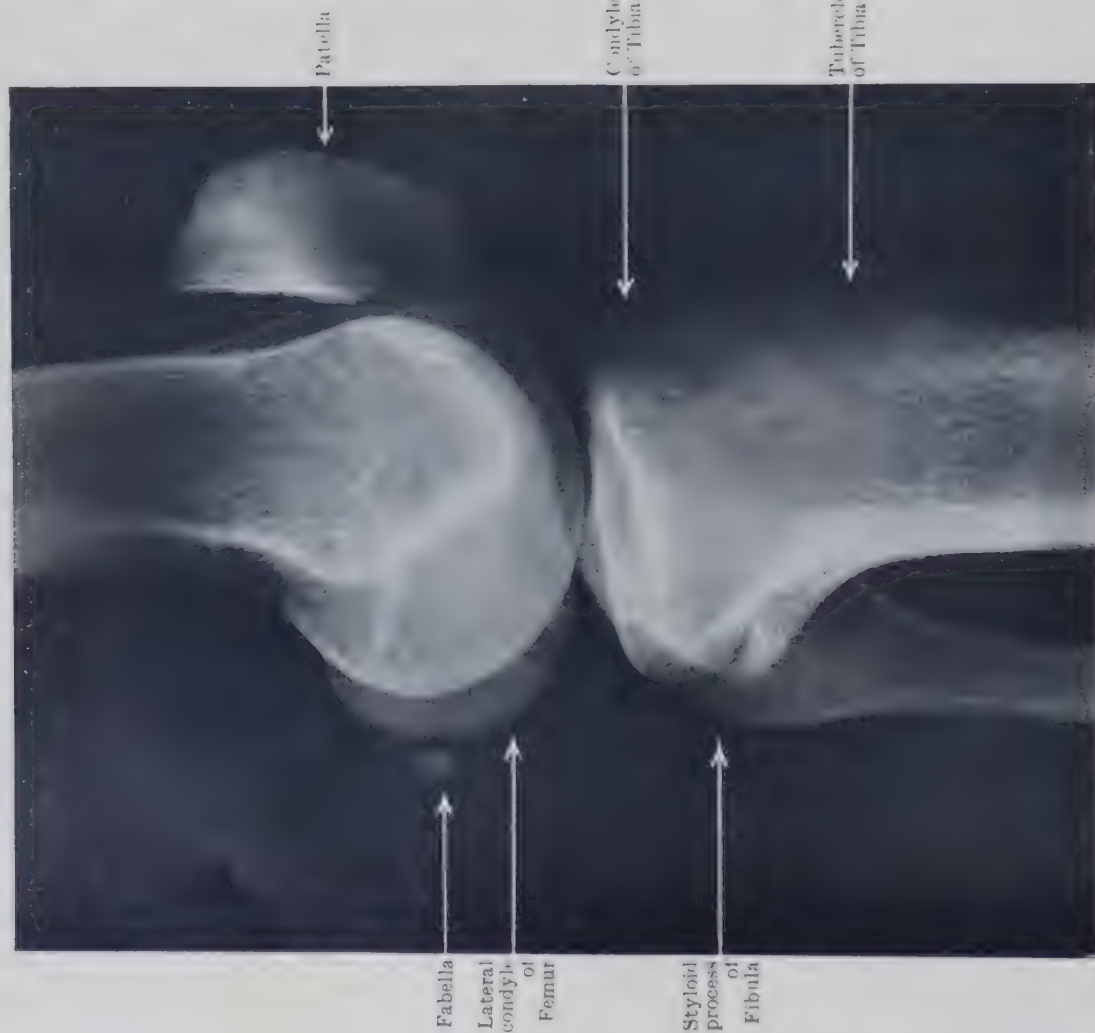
LATERAL RADIOGRAPH OF LEFT KNEE OF YOUNG MAN AGED 22, IN EXTENSION.
